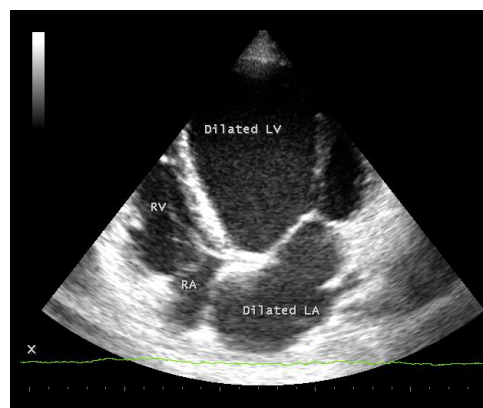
Apical 4 chamber view showing dilated LV cavity on echocardiography.
